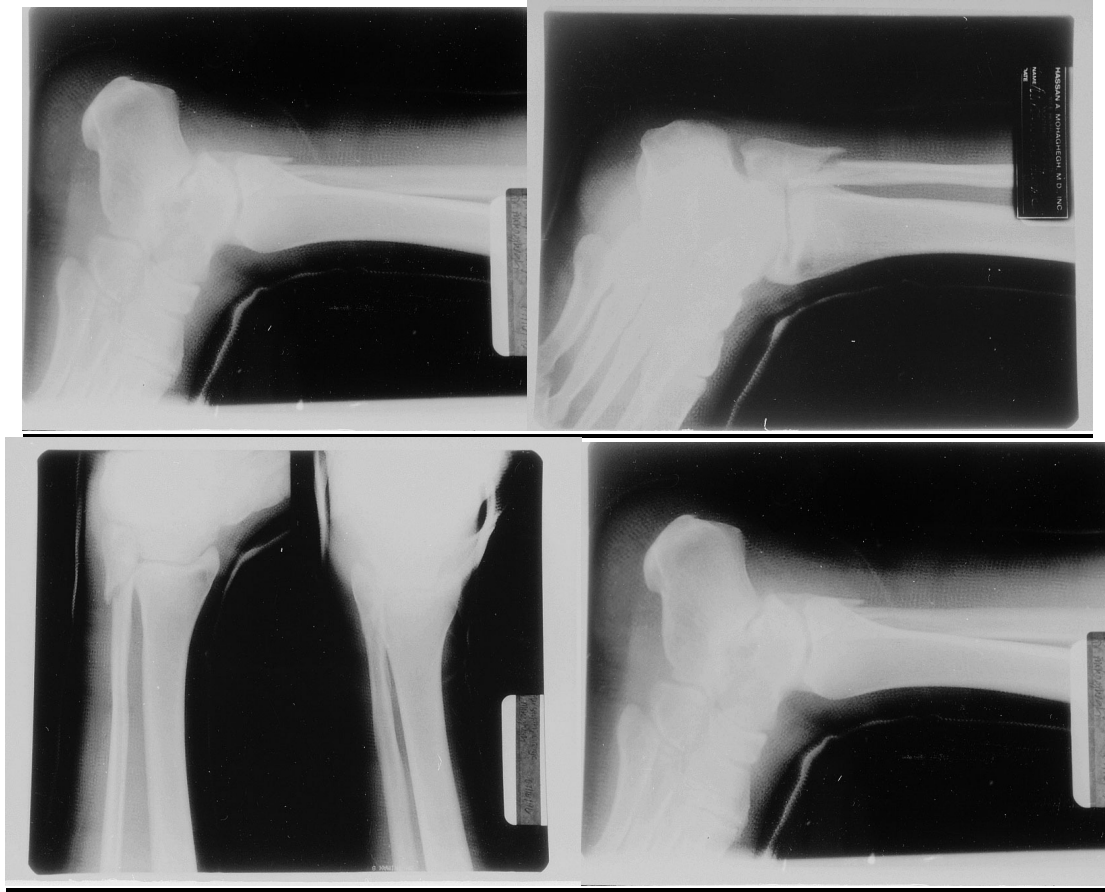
Radiographs from PWC File 14.
